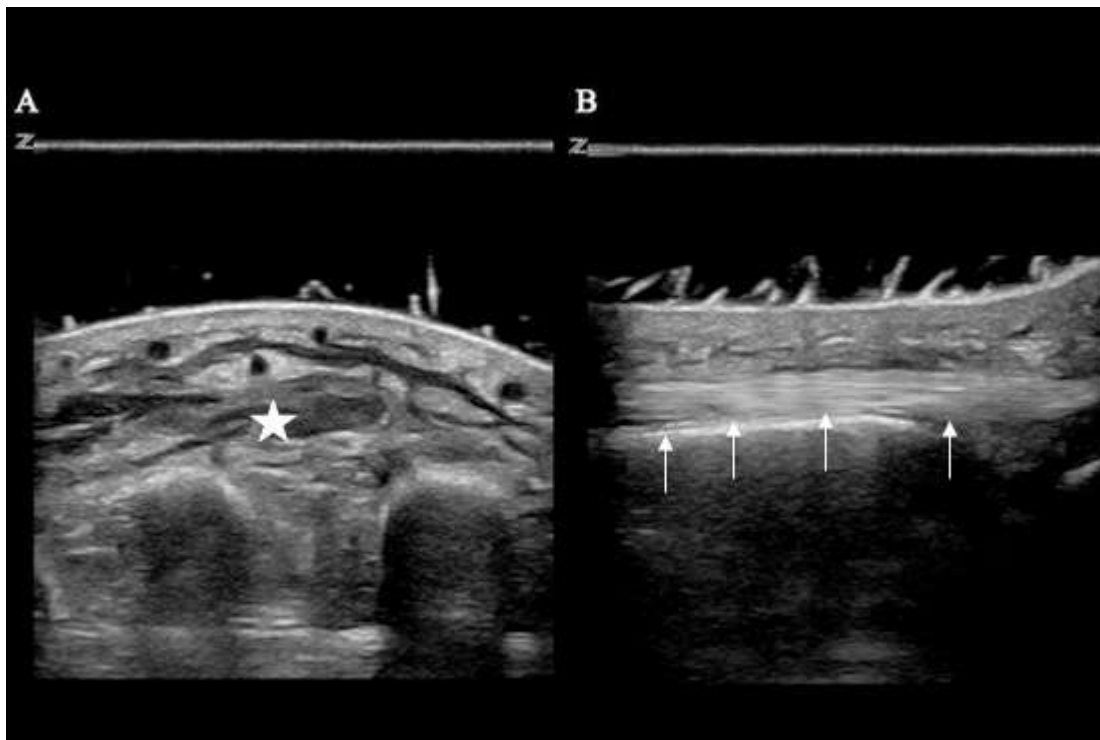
Ultrasound with water bath of a patient's hand with infiltration of the vein due to intravenous cocaine injection. (A) Transverse view of the right hand with fluid and cobblestoning within the soft tissue (star) without a discrete abscess or fluid collection. (B) Longitudinal view of the right hand extensor tendon (arrows) without a discrete fluid collection.
